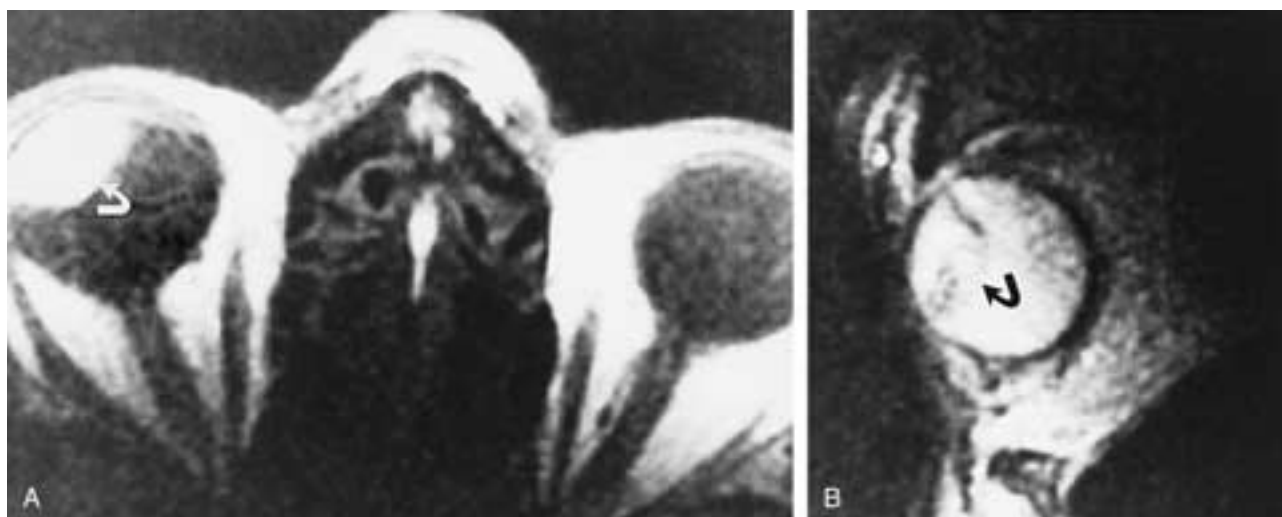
Malignant uveal melanoma. A, Axial T1-weighted MR image shows a hyperintense mass (arrow). B, Sagittal T2-weighted MR image shows the mixed signal appearance of the lesion (arrow). The anterior portion is hyperintense because of necrosis or hemorrhage.
